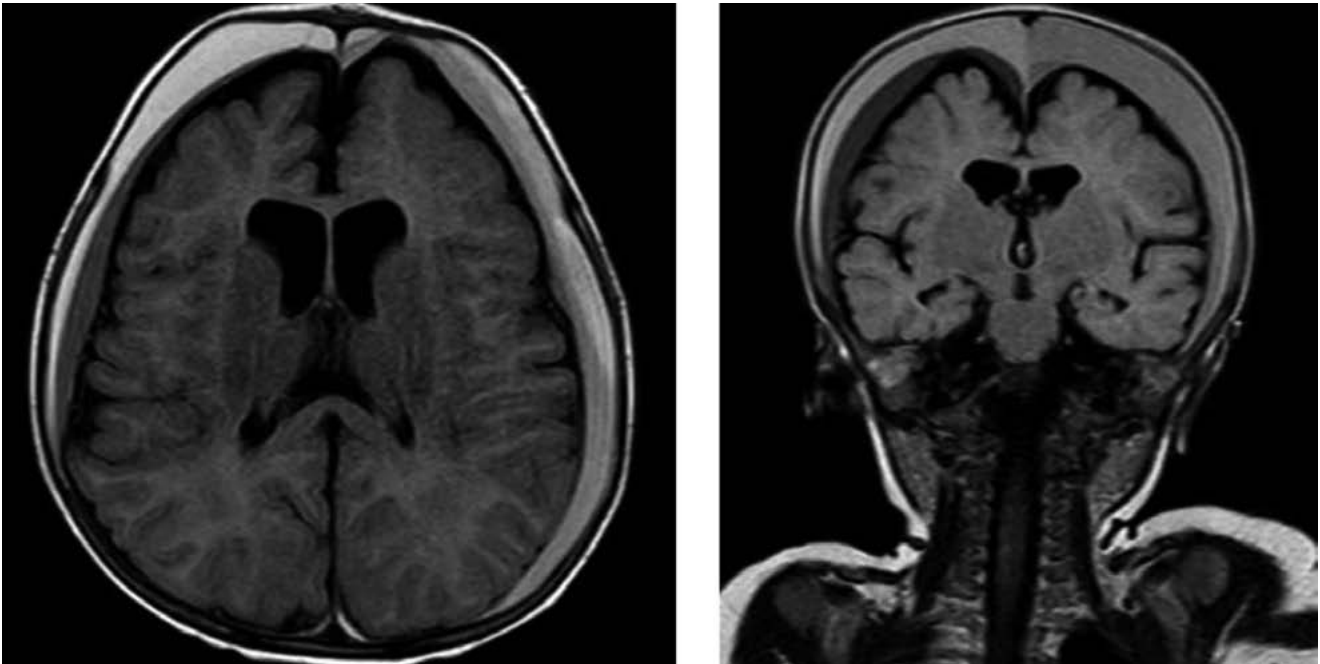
Brain MRI of Case 2, axial and coronal FLAIR sections depicting bilateral subdural hematomas.
